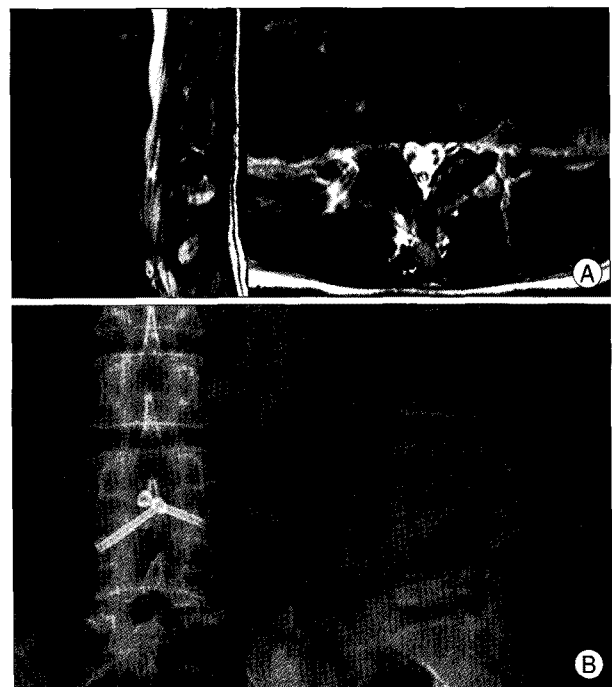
T2-weighted MRI (A) and plain radiographs (B) 4 years after anterior lumbar interbody fusion (ALIF) with percutaneous facet screw fixation (PFF) demonstrate complete resolution of the infection and subsequent solid fusion of the L4-5 segment.
